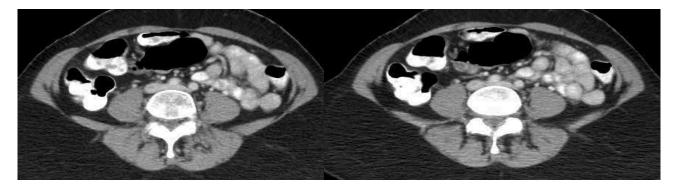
Computed tomography venography demonstrating left iliac vein compression.
